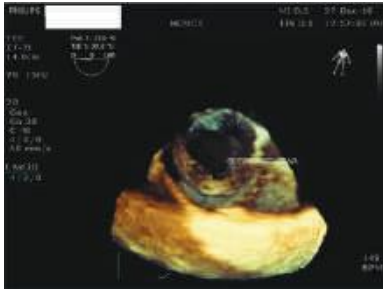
3D-Transesophageal echocardiogram view from the right atrial side revealing a small defect in the aneurysmal sac.
